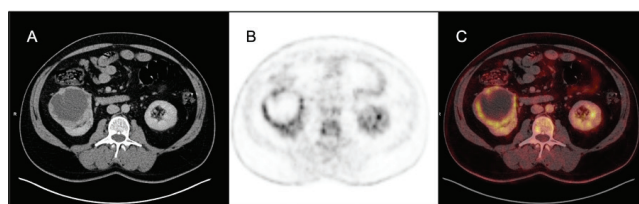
Axial CT (A), PET (B), and fusion PET/CT (C) images of a 54-year-old man patient with clear cell type RCC. The patient had stage 3 cancer with a T3 tumor on PET/CT performed at the initial staging. Primary tumor SUV_{max} was 6.5. He died of recurrent metastatic disease 2.7 years after initial evaluation ^{18}F -FDG PET/CT
